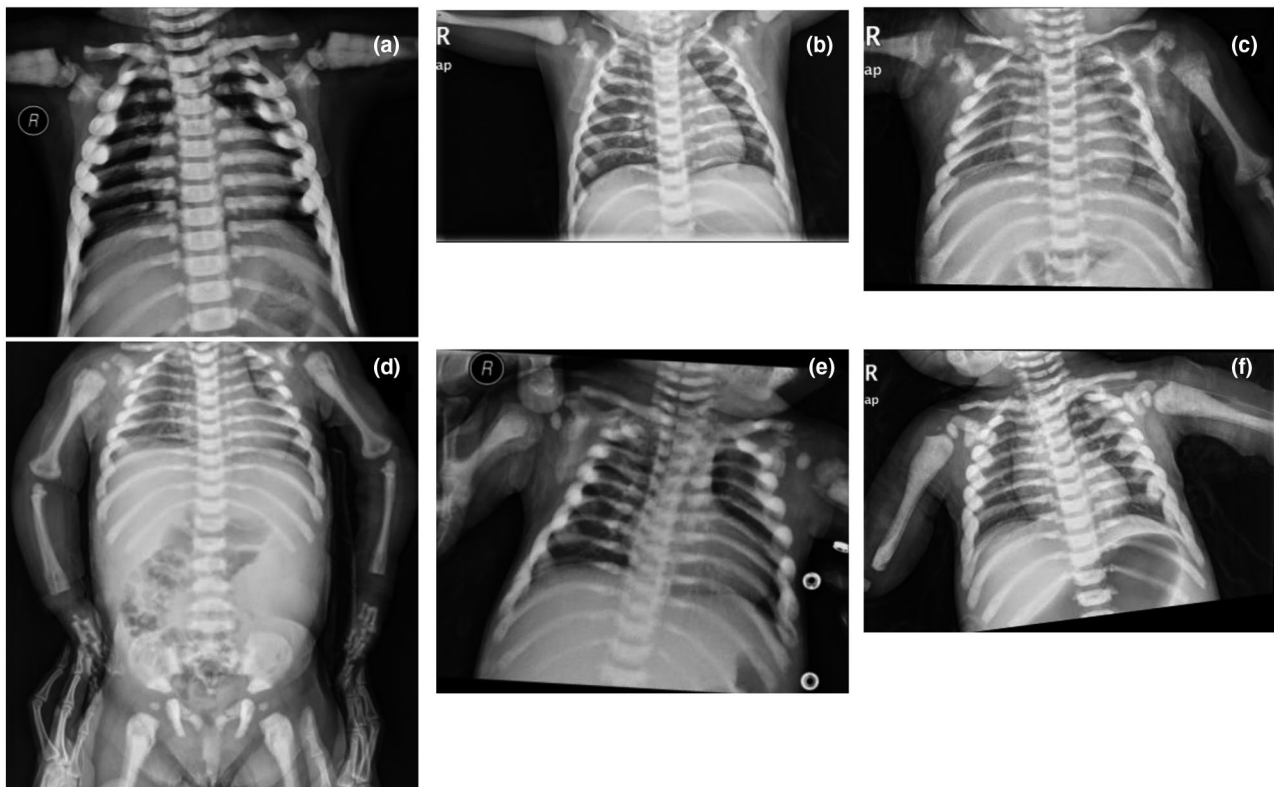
Patient X-rays. Patient 1 (a) A significant increase in bone density was observed, and the vertebral endplate showed the typical “sandwich vertebrae” appearance. Patient 2 (b) The results showed that bone density increased, part of the medullary cavity disappeared, the vertebral endplate thickened, and the “sandwich vertebrae” appearance was observed. Patient 3A (c) A significant increase in bone density was evident. Patient 3B (d) Diffusely increased bone density was confirmed, and the long bones with obliterated marrow cavity showed the typical “bone in bone” appearance. Patient 4 (e) A diffuse increase in bone density was observed, and the marrow cavity of the long bones disappeared, showing the “bone in bone” appearance. Patient 5 (f) A generalized increase in bone density was evident, the marrow cavity of the long bones disappeared, and the vertebral endplate appeared thickened, having the “sandwich vertebrae” appearance
